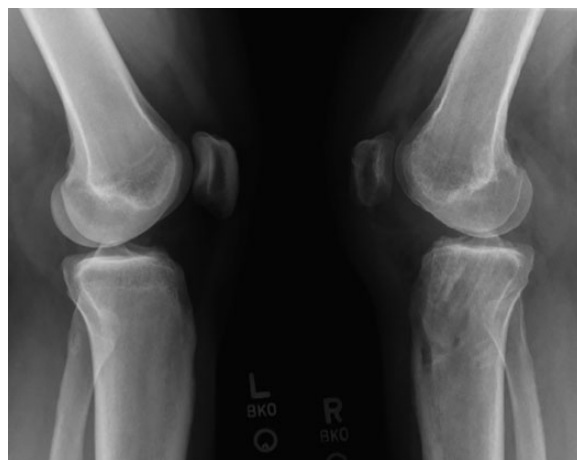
Three-month postoperative lateral radiographs of bilateral knees.
